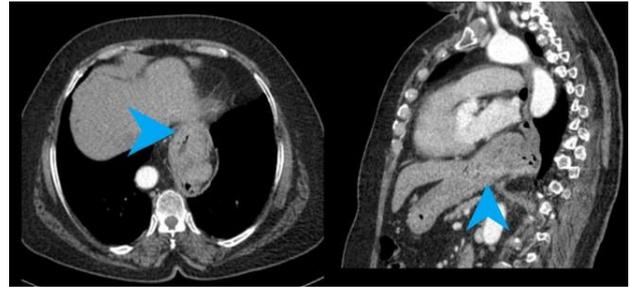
Axial and coronal oblique non-contrast thoracic CT images showing a type 1 hiatal hernia
